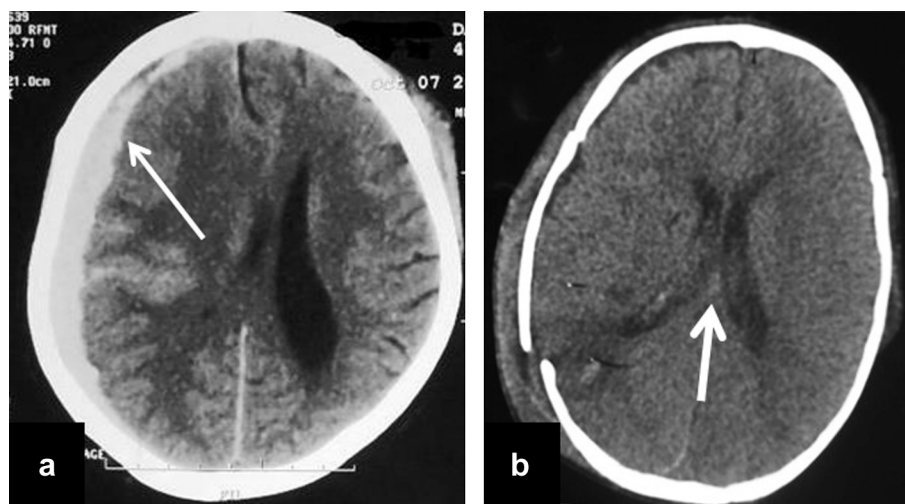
(a) CT scan of brain showing hyperdense biconvex lesion in the Rt. frontotemporoparietal region suggestive of acute subdural hematoma (ASDH) with mass effect. (b) Repeat CT scan of brain on postoperative day – 4 showing complete evacuation of ASDH without mass effect.
